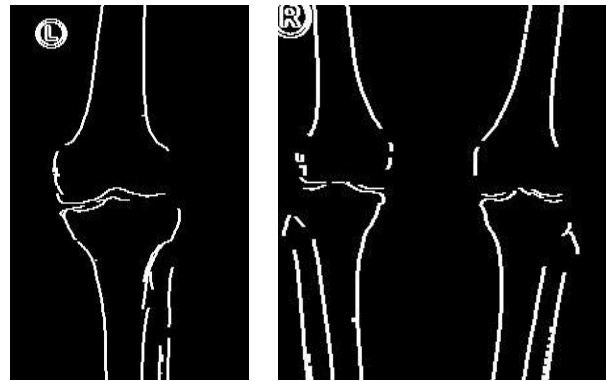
Bone edges of knee radiography image
